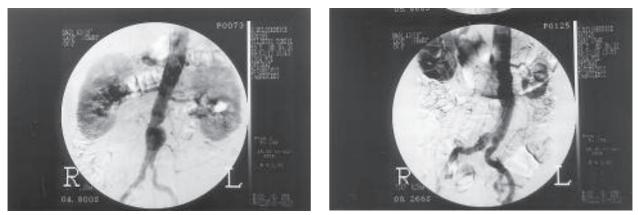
Angiography and CT scans of patient 1: infrarenal abdominal aortic aneurysm with largest diameter of 4.5 cm.
